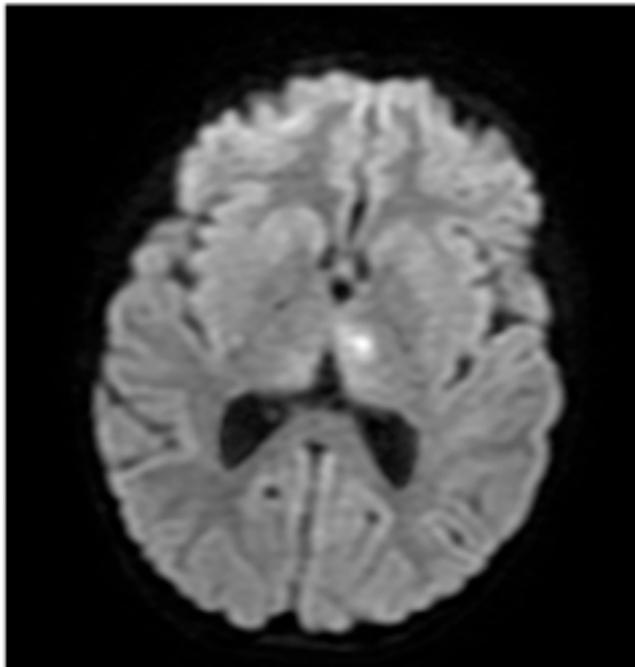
A-C: T2 (A), FLAIR (B) and diffusion sequence (C) MRI of the brain of a 6 year-old-boy (patient 2) obtained 1 week after DKA treatment showing an infarction of the left thalamus extending to the left cerebral peduncle.
